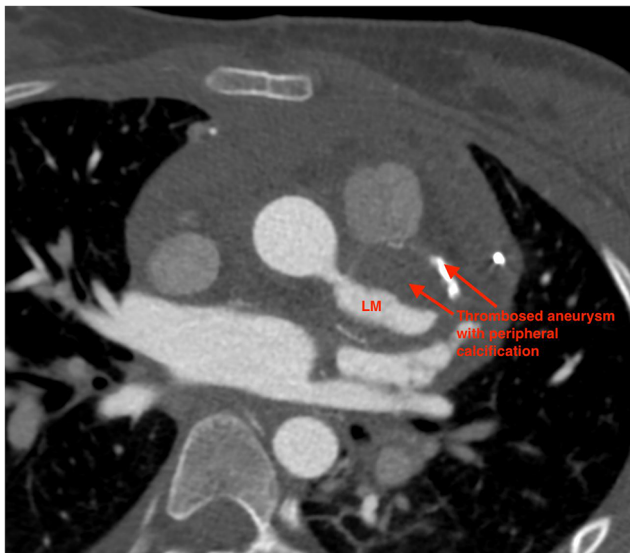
Preoperative CT angiography showing giant CAA of distal left main with thrombosis and peripheral calcification
